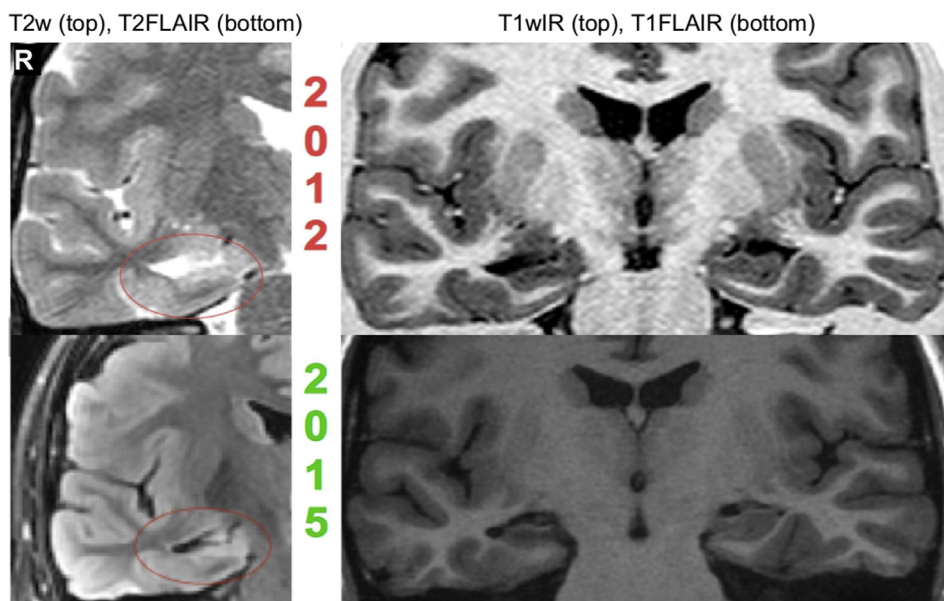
Patient 56: right HS with parahippocampal WM blurring. In 2012 this patient received imaging at a general hospital (left: T2-w; right: T1-w Inversion Recovery) with an angulation not orthogonal to the long axis of the hippocampus. HS and parahippocampal WM blurring are more conspicuous on the epilepsy research image of 2015 (left: T2-FLAIR; right: T1-FLAIR), particularly relative to the contralateral hemisphere. R = right.
